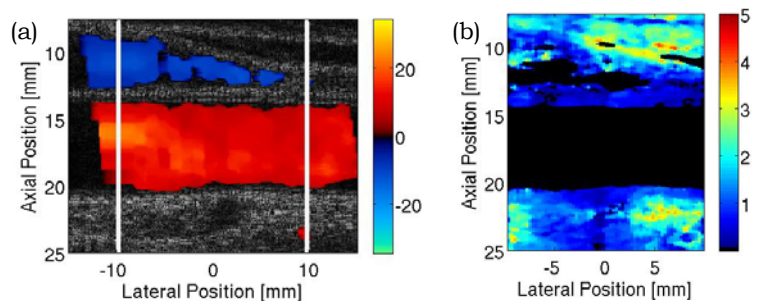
Captured single frame image, showing co-registered B-mode with (a) color Doppler (cm/s) and (b) ARFI displacement (μm) taken from a sequence acquired at a triplex frame rate = 40ms/frame of a carotid artery (lower) and jugular vein (upper) in a normal subject.
